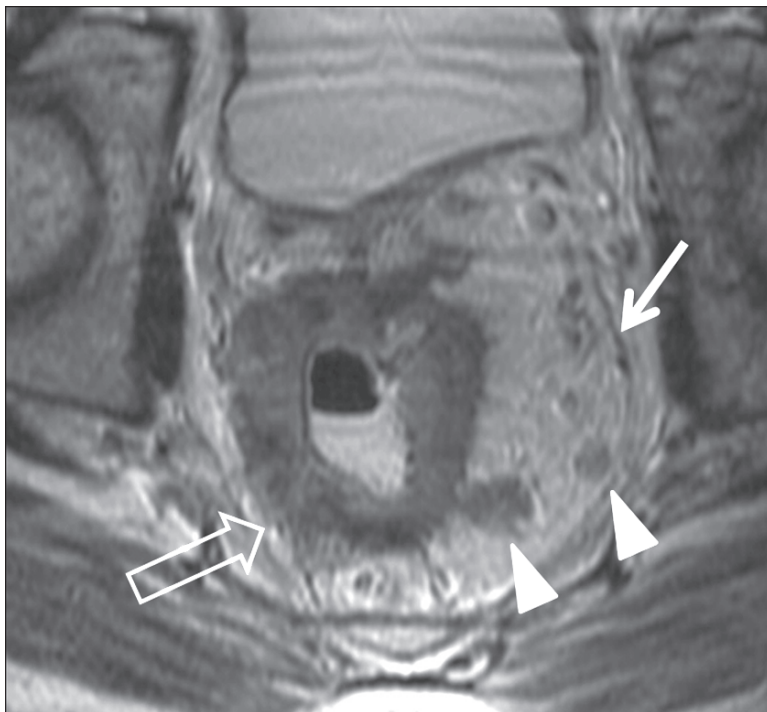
Axial T2-weighted MRI image demonstrates a tumor mass involving the complete circumference of the rectum. The mesorectal fascia is preserved on the left side (arrow), but appears to be involved on the right side (open arrow). In addition, note multiple enlarged perirectal nodes (arrowheads). Other images (not shown) demonstrated clear evidence of invasion of the prostate gland (T4 stage). Case courtesy of Michael A. Blake, MD
